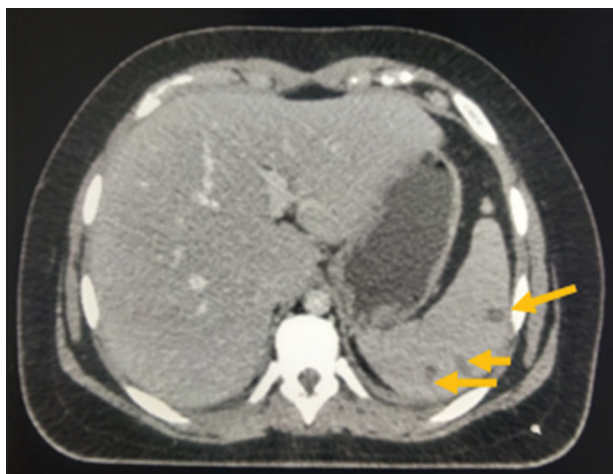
Computed tomography scan of the abdomen performed on day 1 of the second admission shows multiple hypodense foci in the periphery (yellow arrows)
